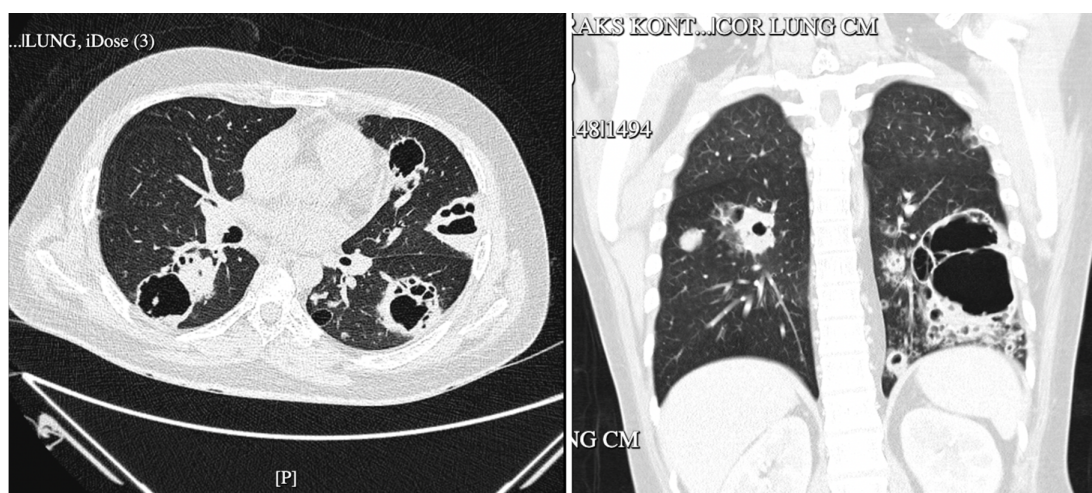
Contrast-enhanced chest CT at initial presentation demonstrating multiple round cavitary lesions, with irregular margins, thick walls, and non-uniform sizes, distributed across segments of both lungs. The dominant lesion is located in the left lung, comprising a large cavity surrounded by coalescent smaller cavities measuring 6 × 7.2 × 12 cm with air-fluid levels. Multiple subcentimeter cavities with similar characteristics and centrilobular micronodules are distributed throughout both lungs, most prominently surrounding the dominant lesion. Diffuse ill-defined centrilobular nodular ground-glass opacities are noted predominantly in the upper lobes of both lungs, suggestive of interstitial lung disease.
